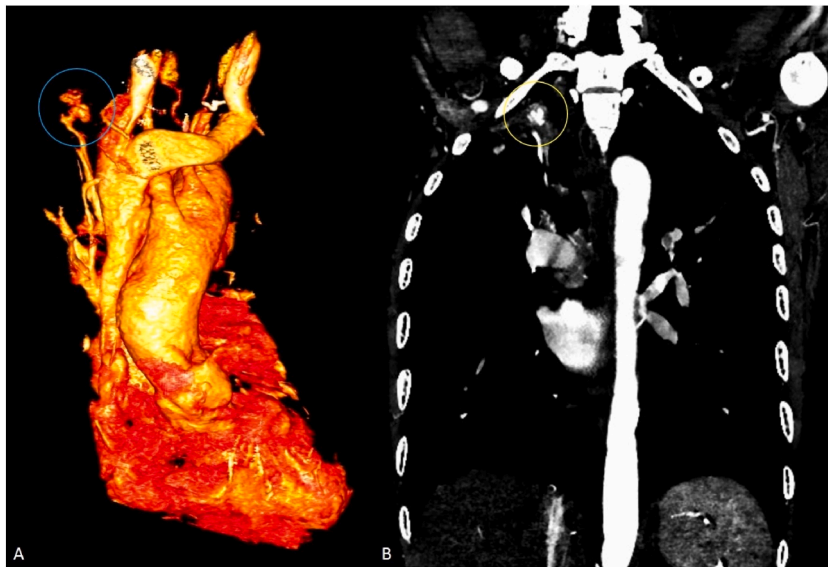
Case 1: CT angiography showing an aneurysm originating from a right upper lobe segmental pulmonary artery branch (yellow and blue arrows).
